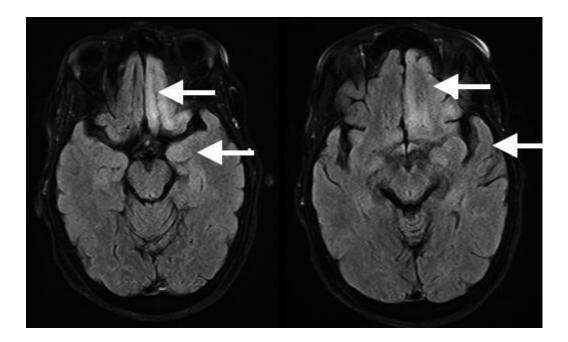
hypersignal in T2 FLAIR-weighted sequences (also present in T2-weighted sequences), in the left fronto-temporal lobe without enhancement after injection of gadolinium in T1-weighted sequences of cerebral MRI (image not shown).
